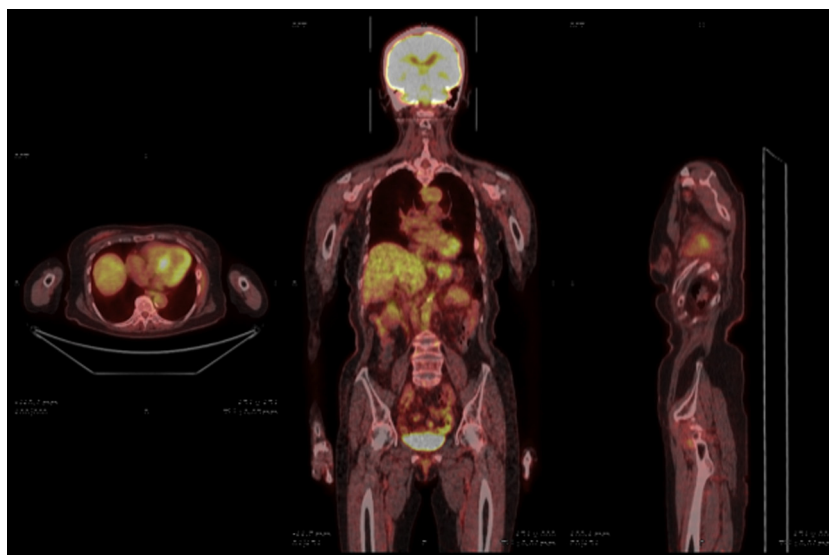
FDG-PET examination revealed accumulation with an SUV_{max} of 2.66 at the left sixth rib.
